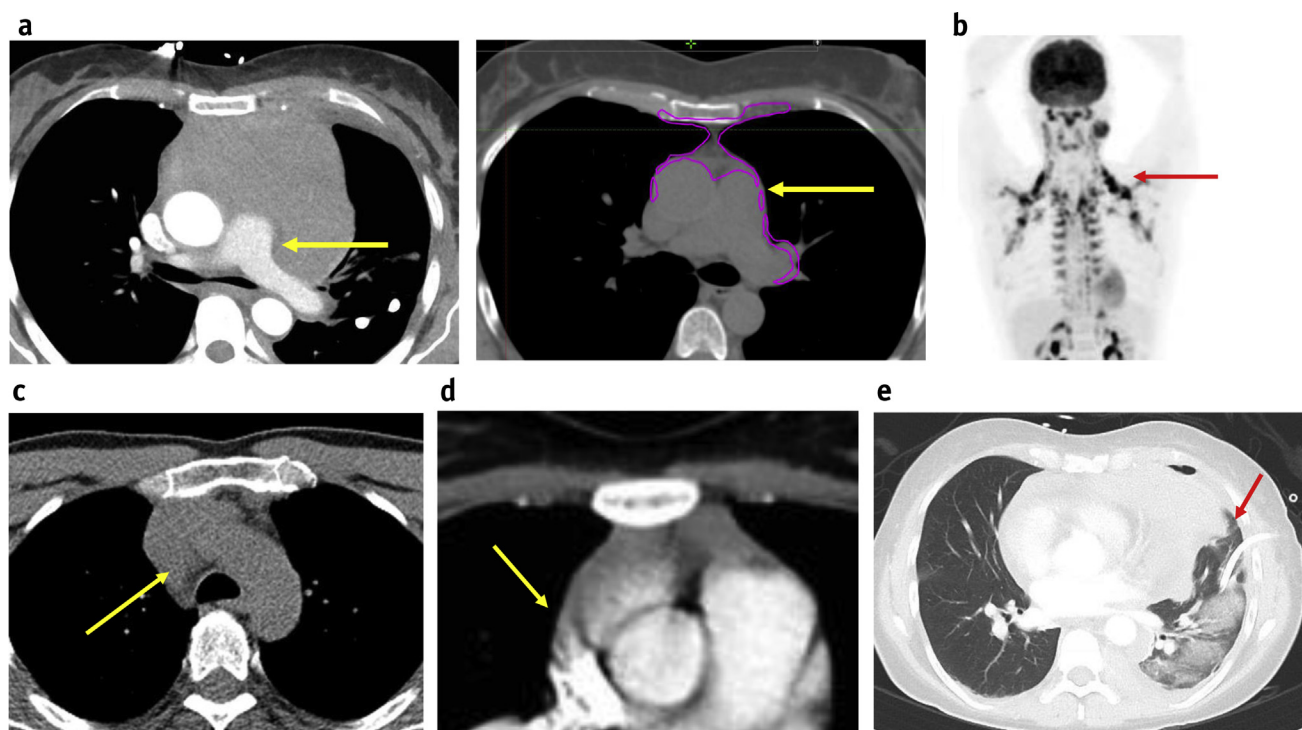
Imaging uncertainties: (a) anatomic shifts after chemotherapy (note the shift of the aorta and pulmonary artery); (b) brown fat potentially obscuring disease; (c) poor anatomic definition with noncontrast computed tomography; (d) ill-defined extent of pericardial infiltration; (e) uncertainty whether lung is displaced or infiltrated.
